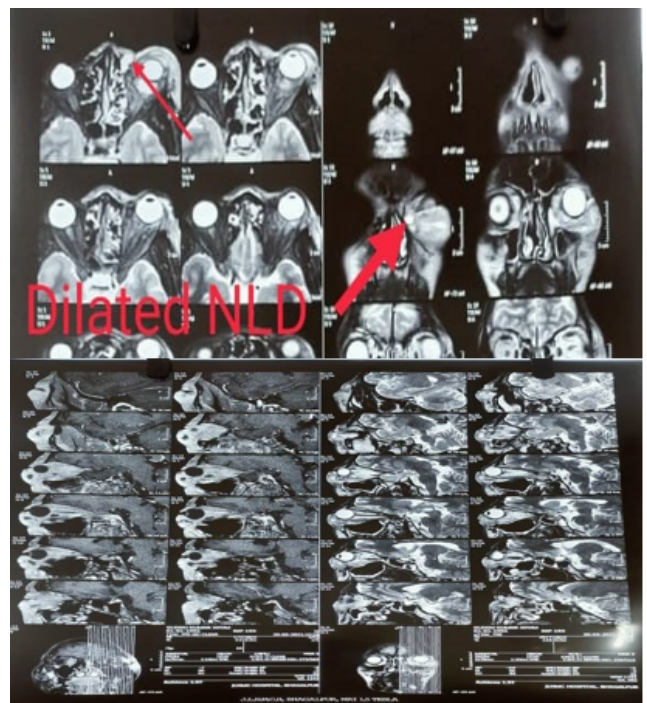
MRI orbit showing enlarged left lacrimal gland.
